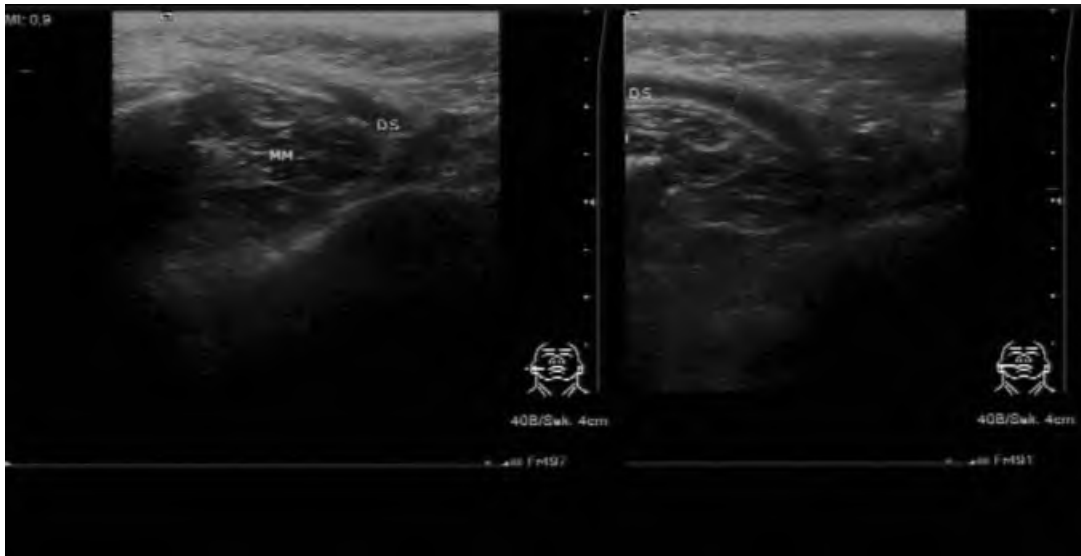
Ascorbic acid stimulation in a patient with distal Stensen's duct stenosis. Left: Transverse sonogram of the right parotid gland before stimulation shows minimally enlarged duct close to the ostium. Right: Sonogram obtained 60 seconds after stimulation shows the entire duct. Abbreviations: DS, Stensen's duct; MM, masseter muscle.
